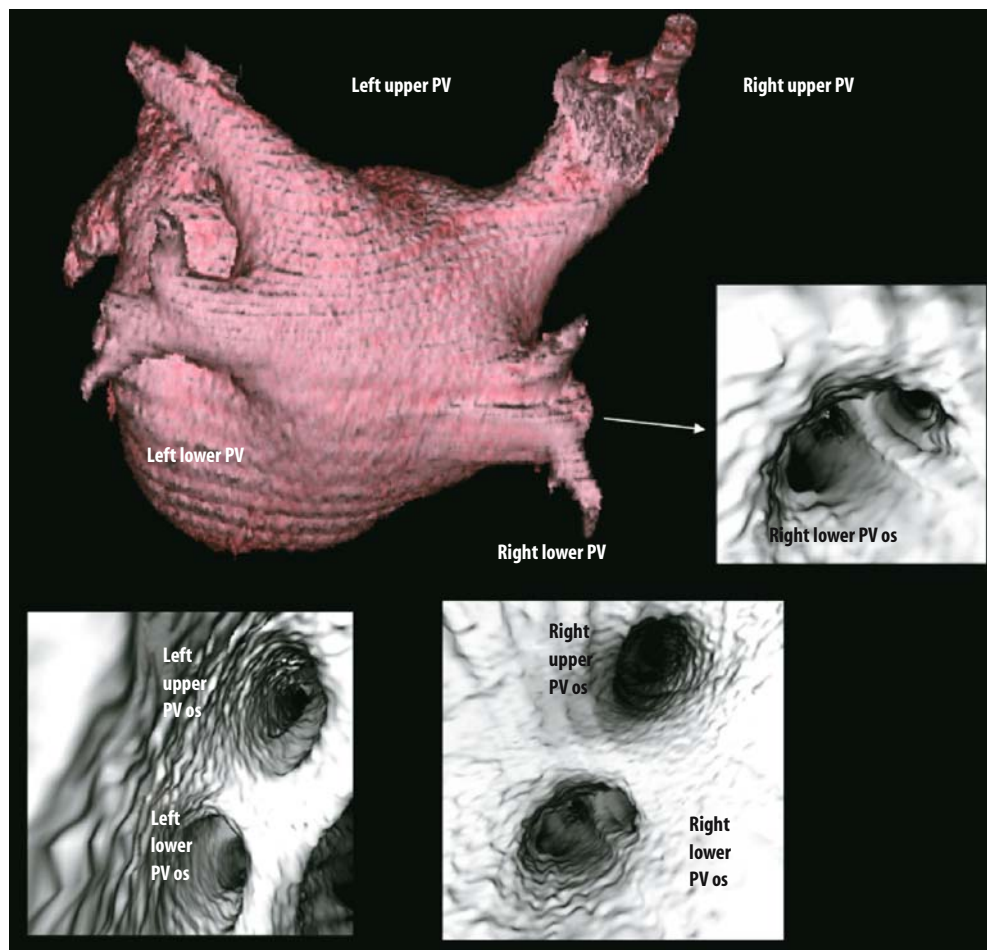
Three-D CT angiography volume-rendered view of the posterior left atrium demonstrating the pulmonary veins. Endocardial views demonstrate venous anatomy, relationships between veins, and pulmonary vein os details. PV = pulmonary vein.
